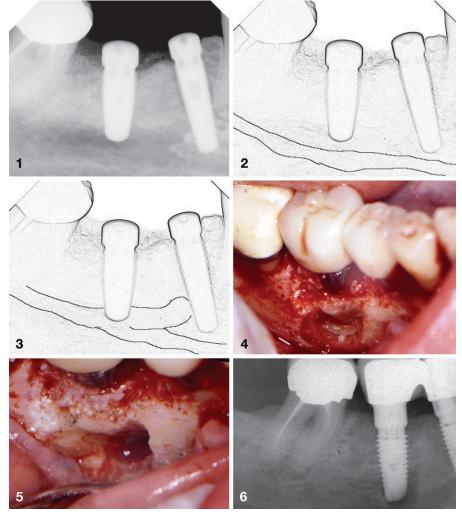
Periapical radiograph of first and second bicuspid implants.
